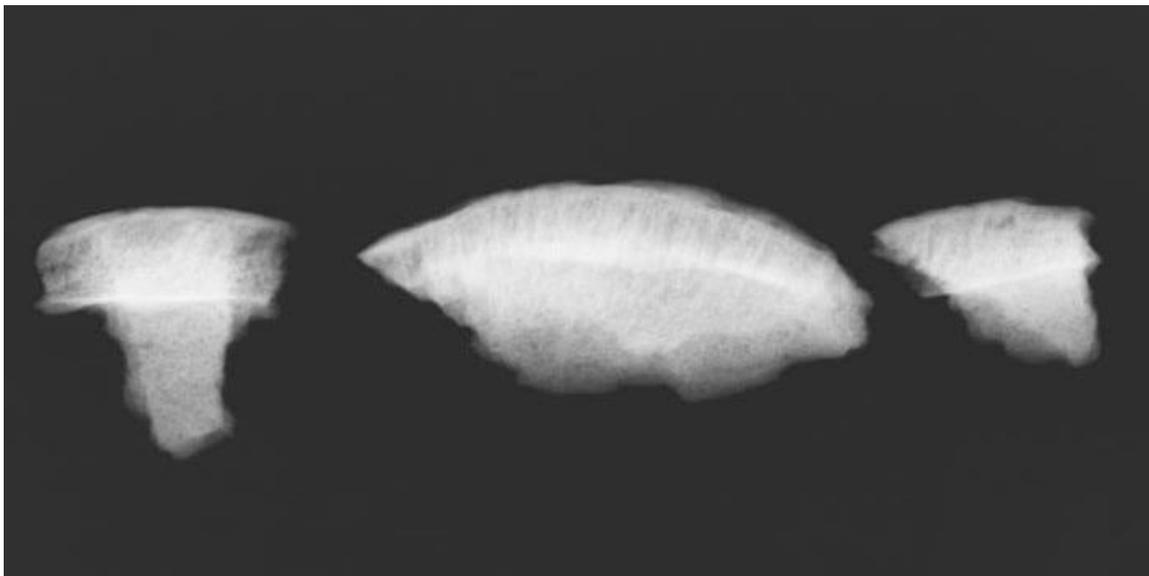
Littleport skeleton 3760 left parietal radiograph showing distinctive diploë 'hair-on-end' appearance (reproduced with permission of G. Western. Image taken by Mark Farmer on behalf of Reveal Imaging Ltd).
